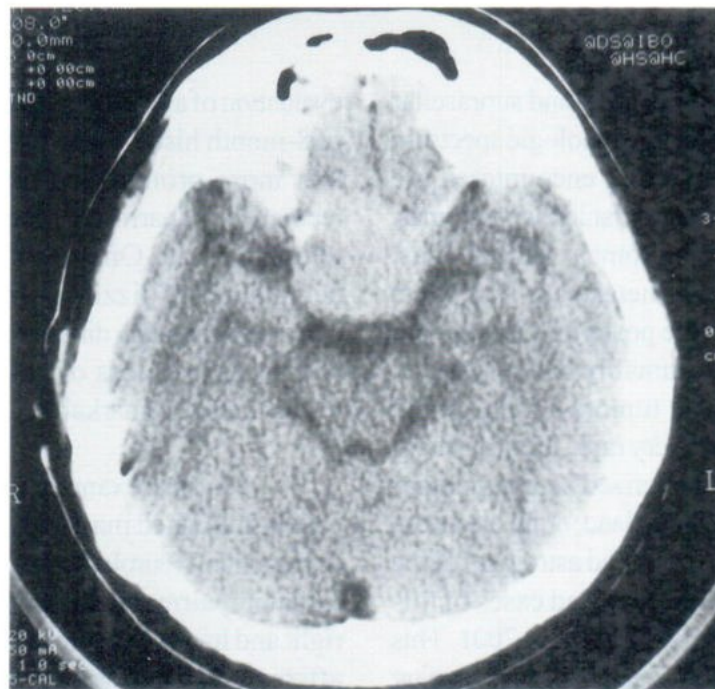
Non-enhanced axial CT scan shows midline homogeneous mild hyperattenuated-solid mass occupying within sellar region with suprasellar extension
